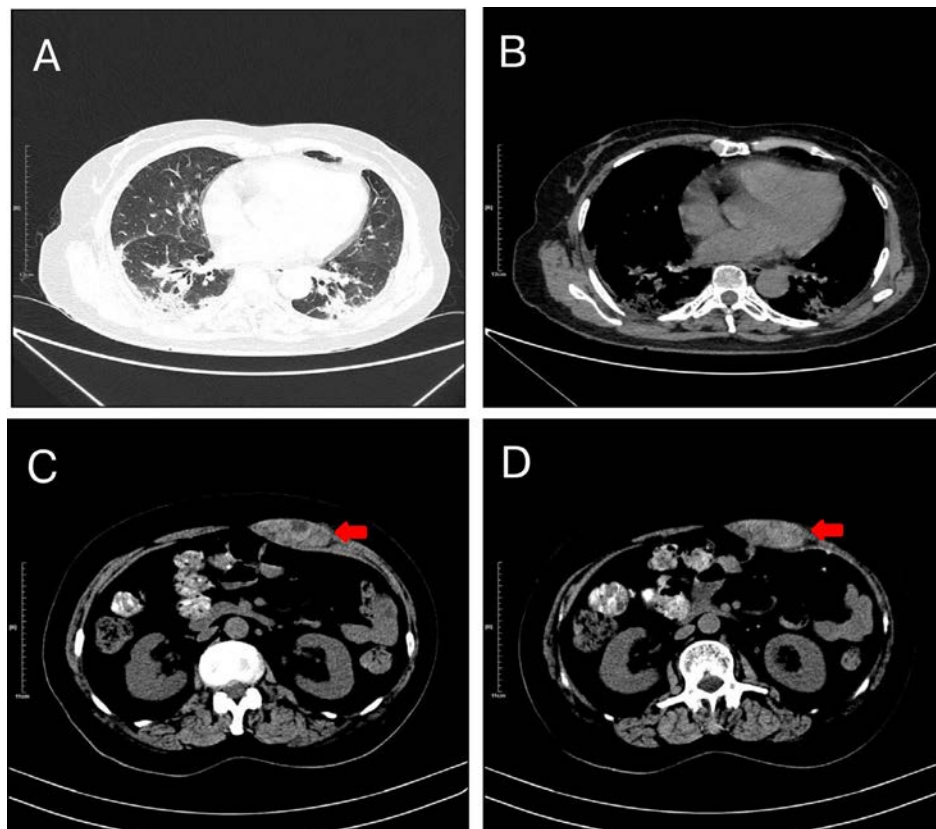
(A, B) Pulmonary high-resolution computed tomography (HRCT) revealed interstitial lung disease characterized by inflammation in both lungs. (C, D) An abdominal CT scan revealed a new-onset hematoma in the left rectus abdominis muscle.
